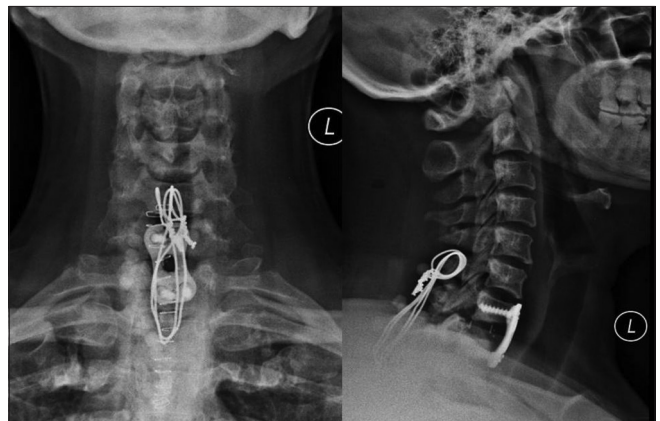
The postoperative X-rays of the cervical spine showing fracture fixation with plate and screws anteriorly (C7/T1) and posterior cervical wiring (C6 to T2)
